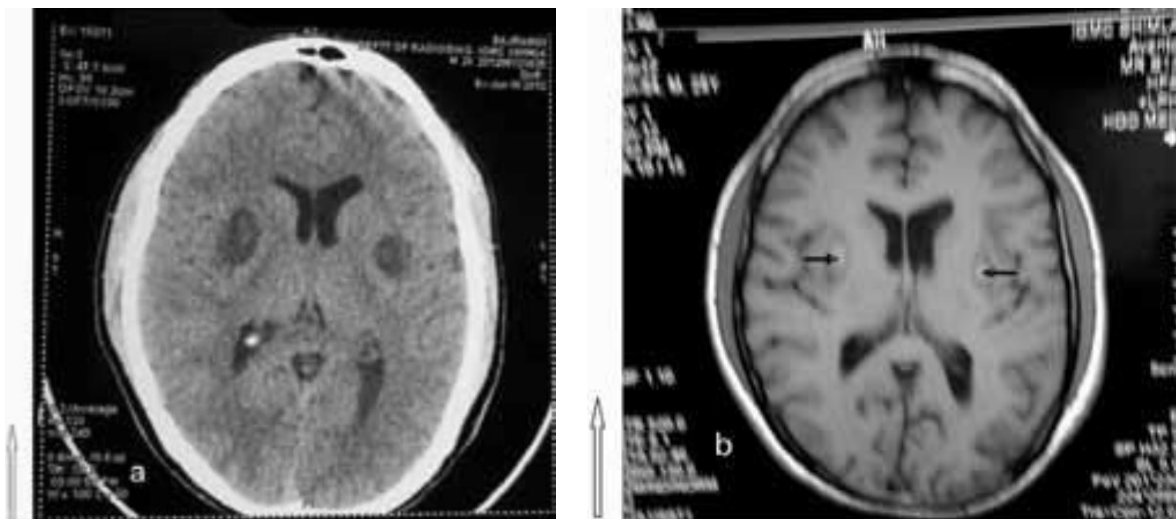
a and b. Non contrast axial CT head (a) showing hypodense areas involving bilateral lentiform nuclei with hyperdense specks within and T1 – weighted axial MR image of brain showing hypointense lesions with central hyperintensities (*arrows*) in putamina, suggesting bilateral putaminal hemorrhagic necrosis.
